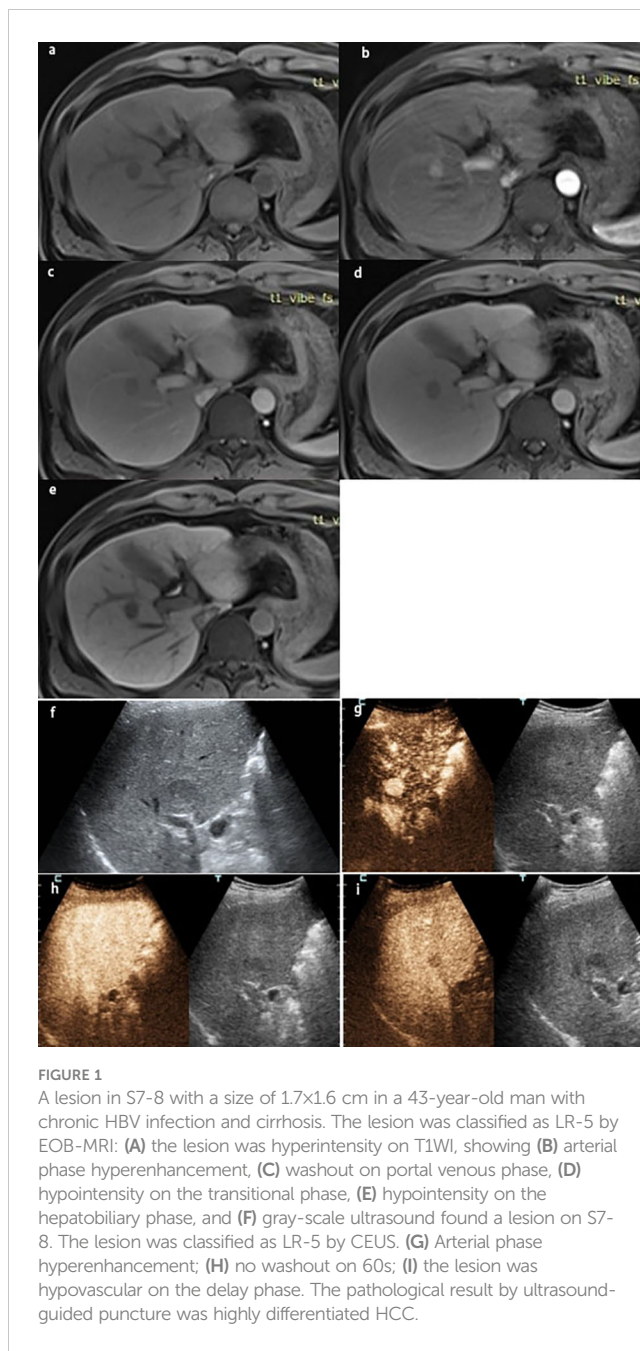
A lesion in S7-8 with a size of 1.7x1.6 cm in a 43-year-old man with chronic HBV infection and cirrhosis. The lesion was classified as LR-5 by EOB-MRI: (A) the lesion was hyperintensity on T1WI, showing (B) arterial phase hyperenhancement, (C) washout on portal venous phase, (D) hypointensity on the transitional phase, (E) hypointensity on the hepatobiliary phase, and (F) gray-scale ultrasound found a lesion on S7-8. The lesion was classified as LR-5 by CEUS. (G) Arterial phase hyperenhancement; (H) no washout on 60s; (I) the lesion was hypovascular on the delay phase. The pathological result by ultrasound-guided puncture was highly differentiated HCC.
